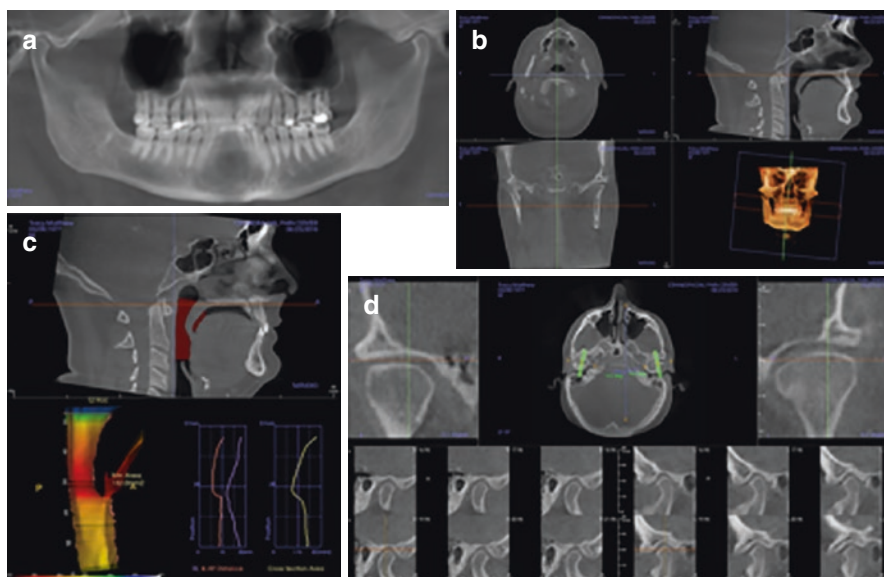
(a) Upper right figure, panoramic view. (b) Upper left figure, CBCT overview. (c) Lower left figure, CBCT evaluation indicates a narrowed oropharyngeal airway posterior to inferior soft palate. (d) CBCT, tomographic view indicates posterior/superior displacement of bilateral TM condyles
